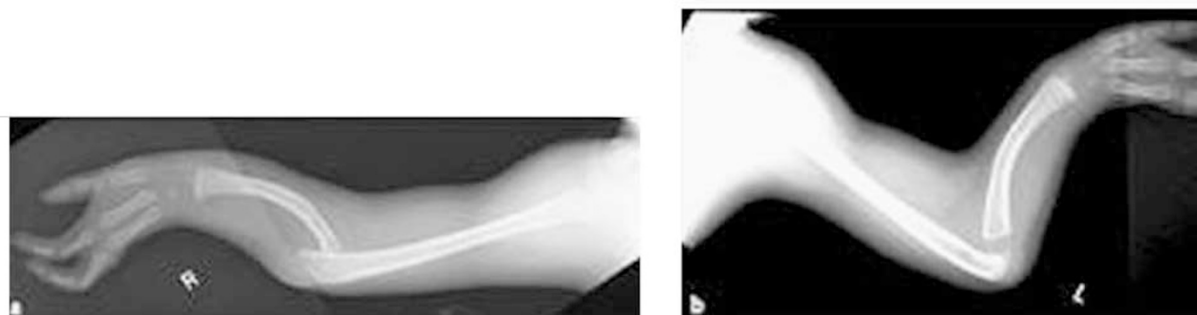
Radiographs of the arms showing bilateral aplasia of ulnae, and absence of fourth and fifth digit including, metacarpalia and carpalia, distal hypoplasia of humeri, bowing with shortening of radii, the only metacarpal bone is the os hamatum. (a) X-ray of the right arm and (b) X-ray of the left arm.
